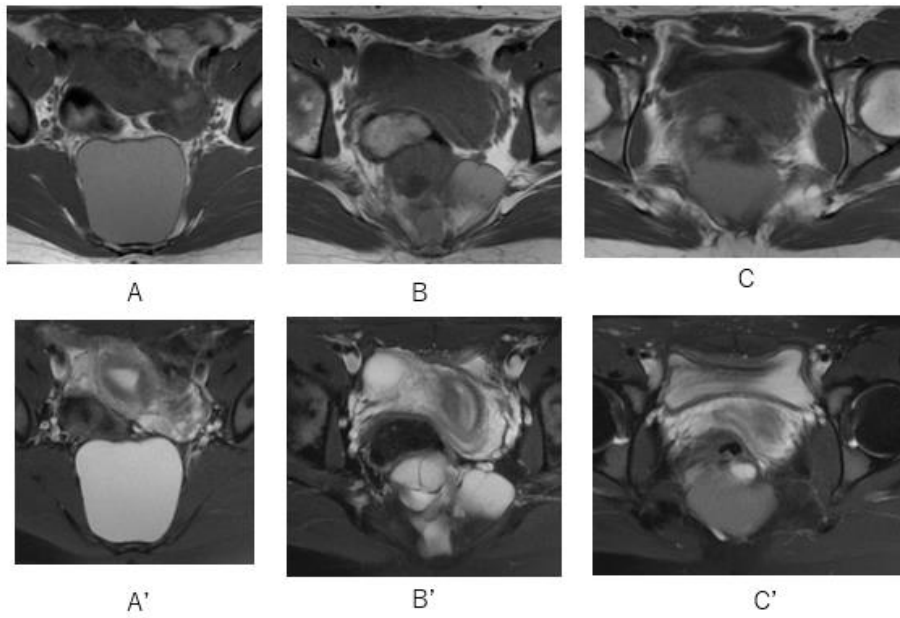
A multi-cystic lesion whose signal intensity differs in each is depicted on axial MRI with T1WI (A-C) and fat suppression T2WI (A'-C').
